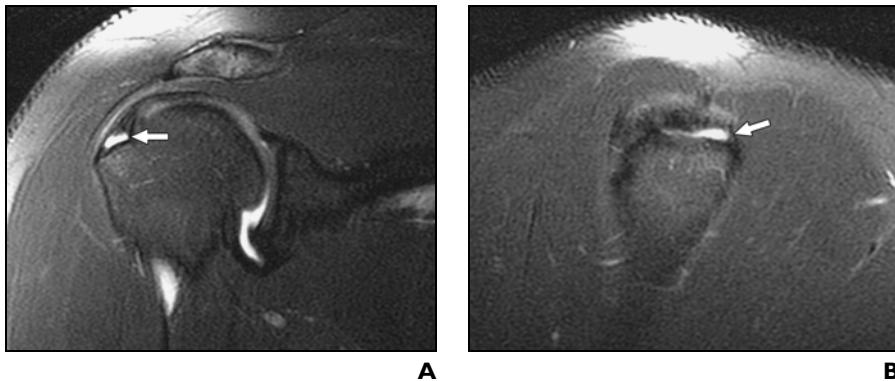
25-year-old man with rim-vent tear of supraspinatus tendon. A and B, Fat-suppressed fast spin-echo T2-weighted coronal oblique (TR/TE, 3,967/65) (A) and sagittal oblique (3,850/75) (B) MR arthrography images show rim-vent tear (*arrows*) at insertion of supraspinatus tendon onto greater tuberosity.
